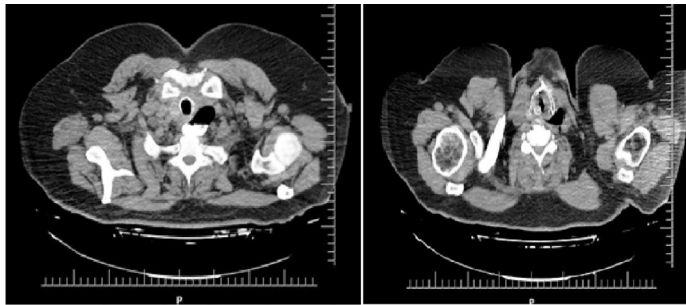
CT images of Zenker diverticulum
